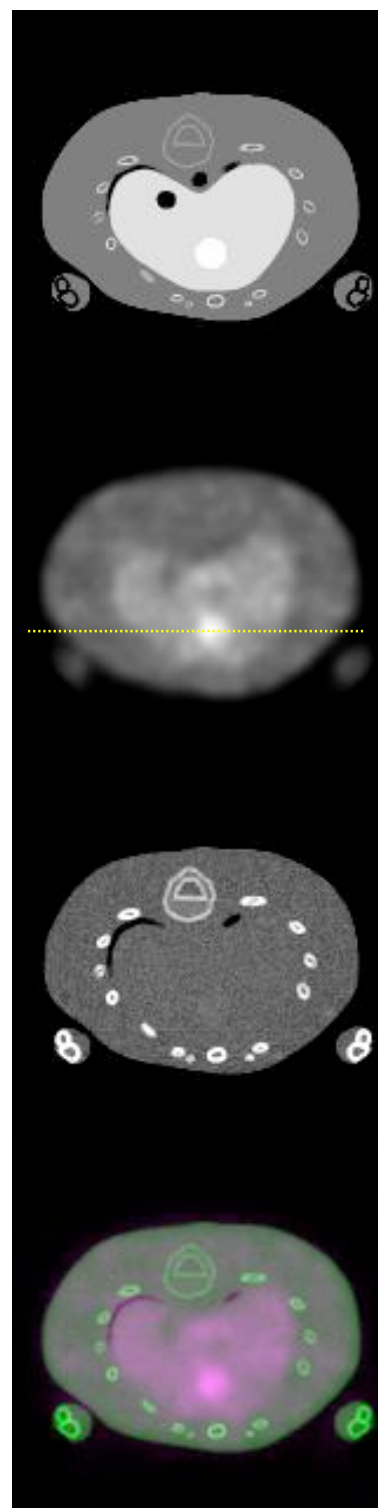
Top to bottom: ^{18}F -FDG activity concentrations at different regions; PET image; CT image; fused PET/CT image.
